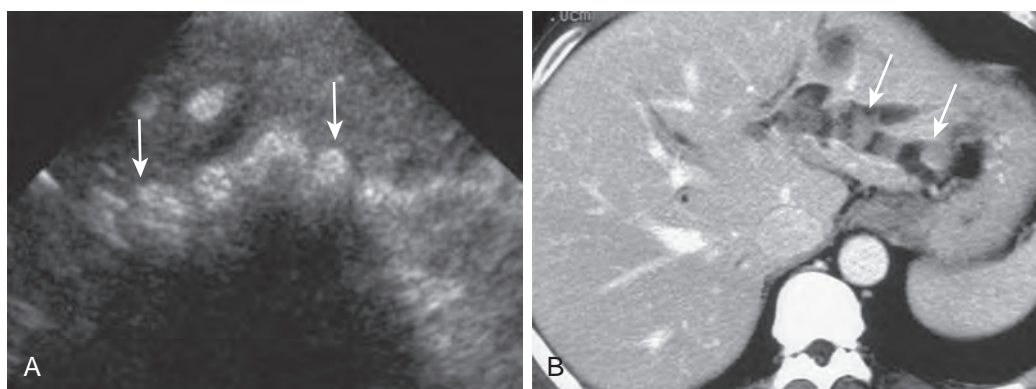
Recurrent pyogenic cholangitis. A. Hepatic ultrasound demonstrates cast of stones in intrahepatic ducts of left lateral segment (arrows). These appear as echogenic material with posterior acoustic shadowing. B. Contrast-enhanced CT demonstrates soft tissue density material in dilated ducts (arrows) corresponding to pigment stones. The lateral segment is primarily involved, a typical feature of recurrent pyogenic cholangitis.
